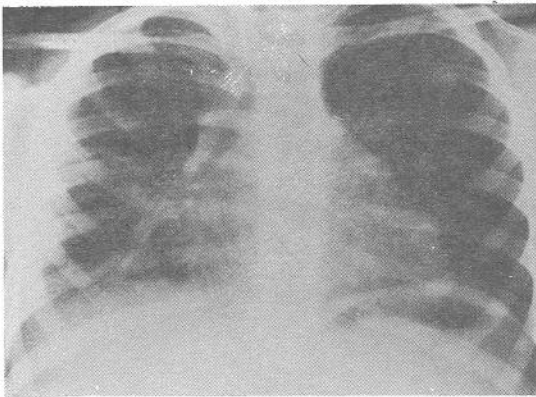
Chest radiograph two weeks after onset of treatment shows marked clearing of the multiloculated right middle lobe abscess, with residual right pleural reaction and areas of atelectasis in the right lower lobe.
